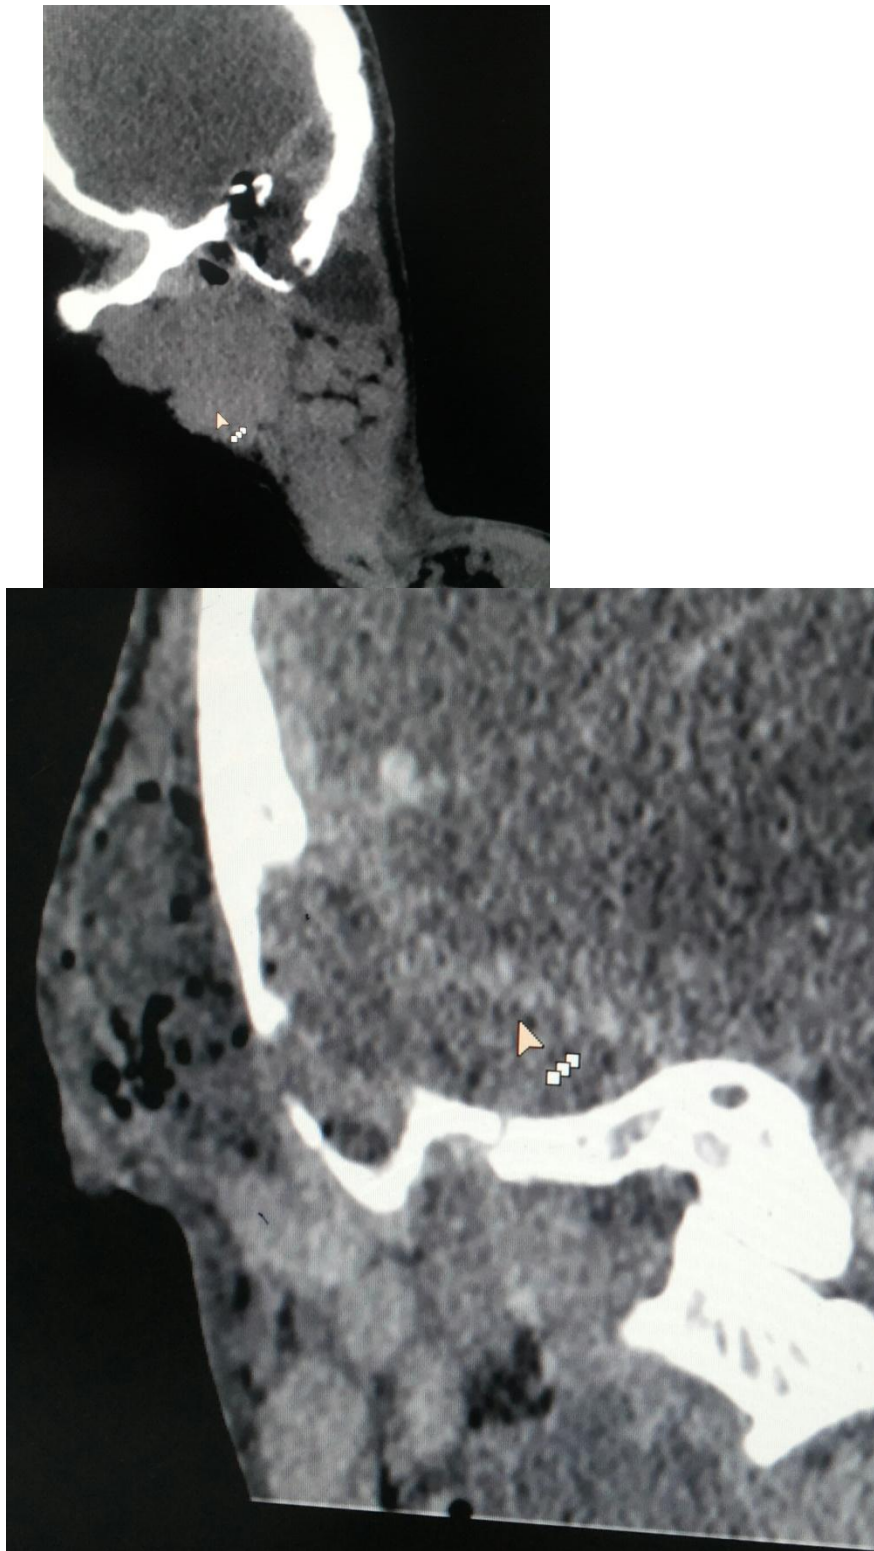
HRCT and CECT shows destruction of the dural sinus plate of sigmoid sinus and perisinus abscess
